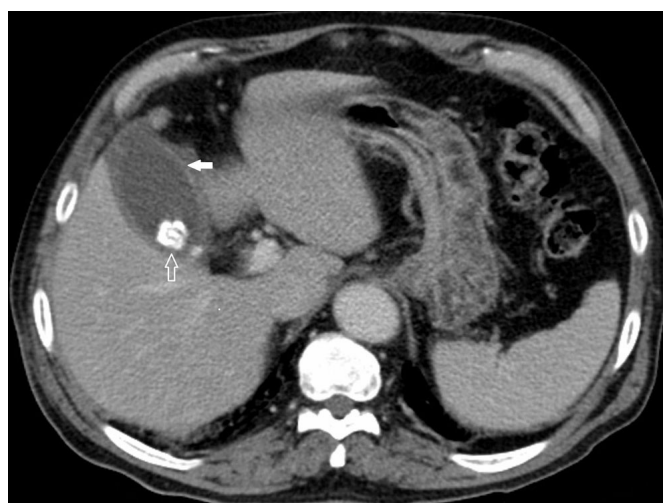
A 78-year-old male patient. Acute cholecystitis was evident on abdominal CT, as indicated by the increased wall thickness of the gallbladder, mucosal enhancement (white arrow), and a calcified stone (open arrow)
